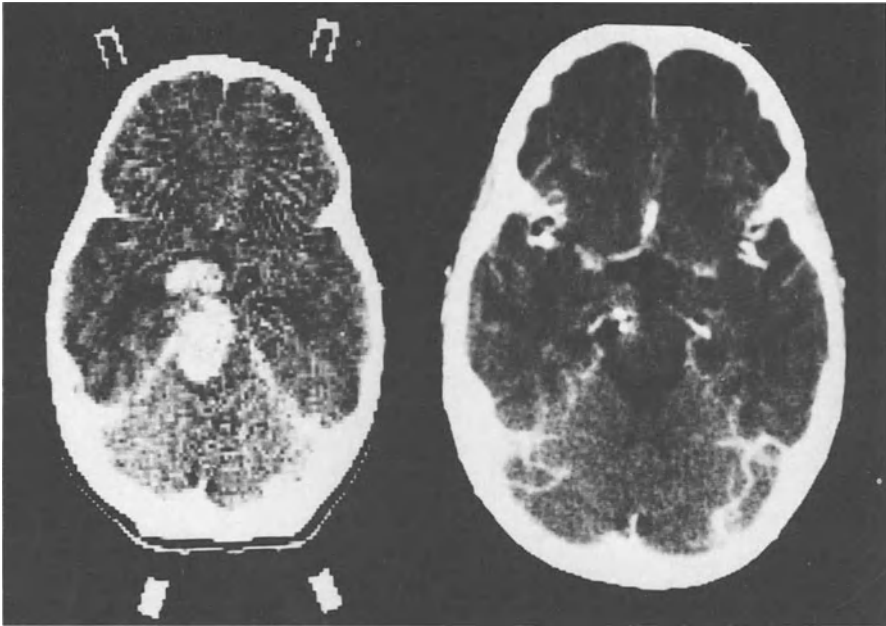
CT examination of a patient with a glioblastoma (Kernohan classification). *Left*, preoperatively; *right*, 4 years after combined interstitial (iodine-125, permanent implantation, 60 Gy) and external beam irradiation (boost dose 15 Gy)
